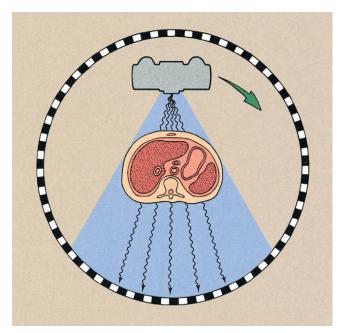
Fourth-generation computed tomography imaging systems operate with a rotating x-ray source and stationary detectors.
